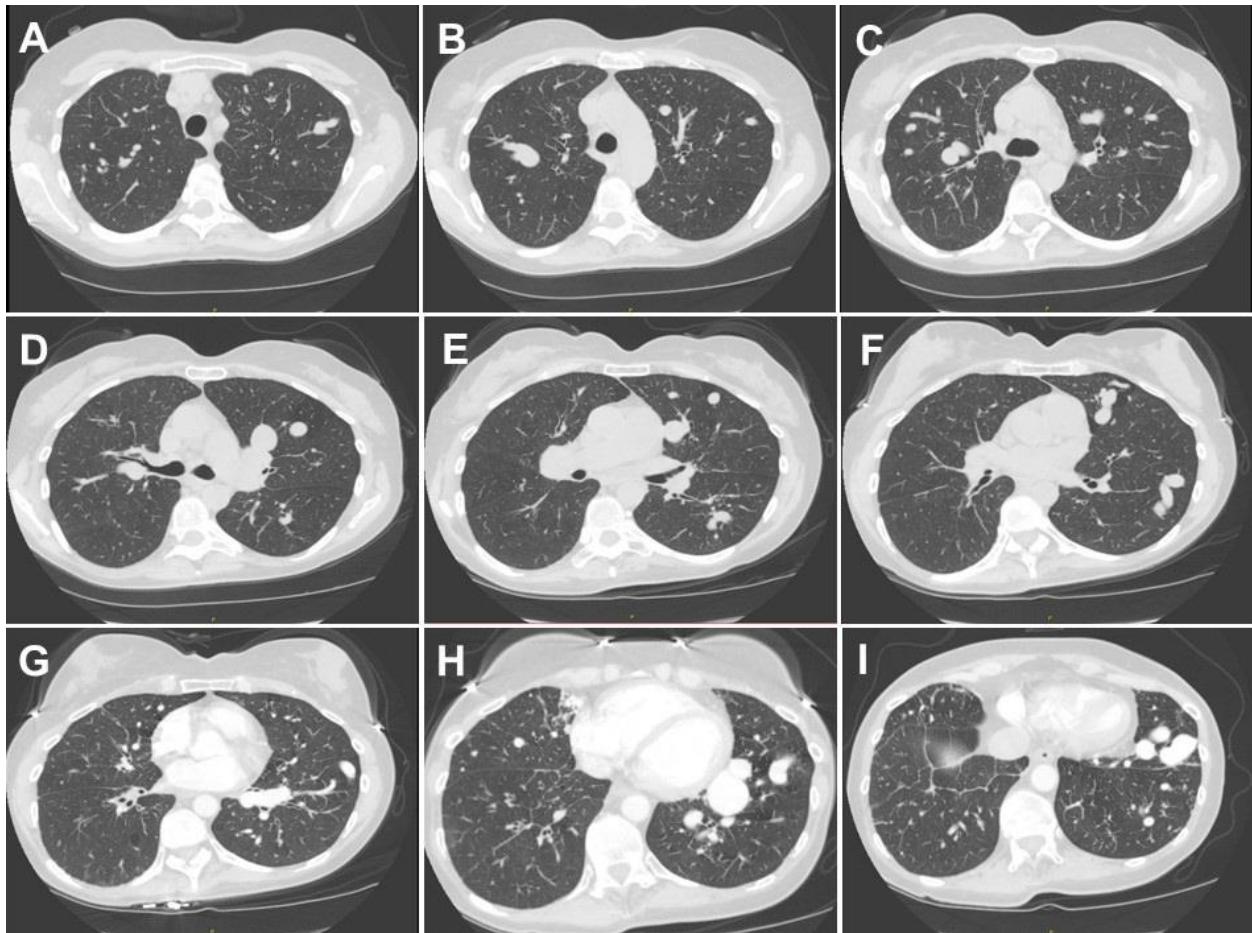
Representative images from thoracic CT scan without contrast (A-F) and with contrast (G-I).
